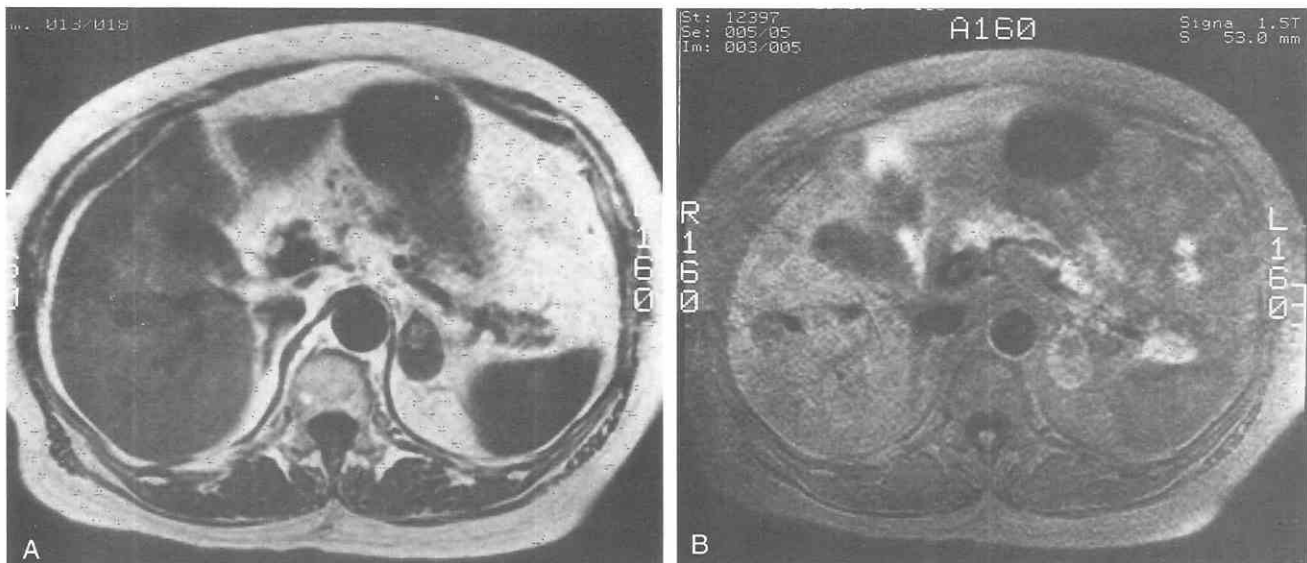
Adenoma. A and B, MR images of a 2.5-cm left adrenal mass. Loss of signal on opposed-phase chemical shift imaging showed that this lesion was a benign adenoma.
